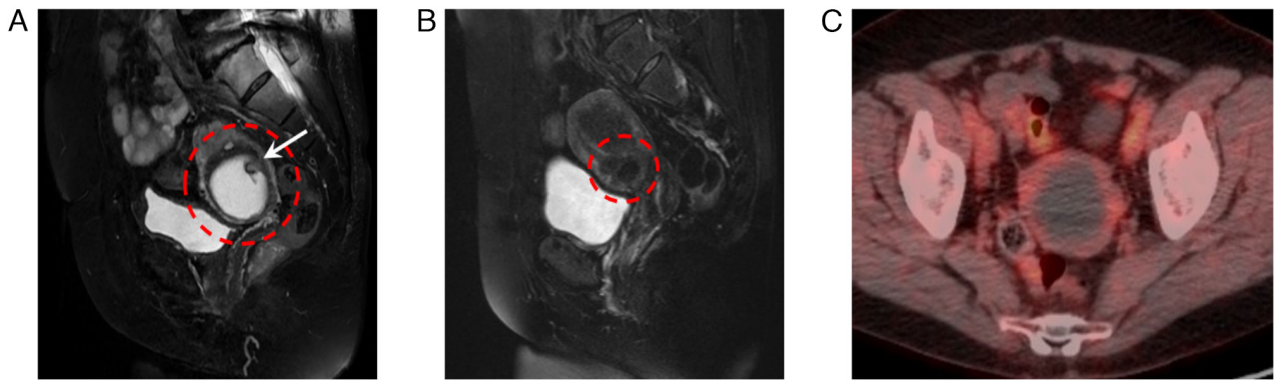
MRI and PET-CT of cystic adenomyosis. (A) T2-weighted MRI of cystic adenomyosis containing the bloody fluid (dotted line). A 5.2-cm cystic mass with a solid part (arrow) was observed within the lower segment of the myometrium. (B) T2-weighted MRI of cystic adenomyosis 17 years ago (dotted line). The presence of a 1.5-cm myoma with bleeding was observed between the myometrium and submucosa. (C) PET-CT image of the cystic adenomyosis. No abnormal accumulation of fluorodeoxyglucose was detected in the cyst wall. PET, positron emission tomography.
